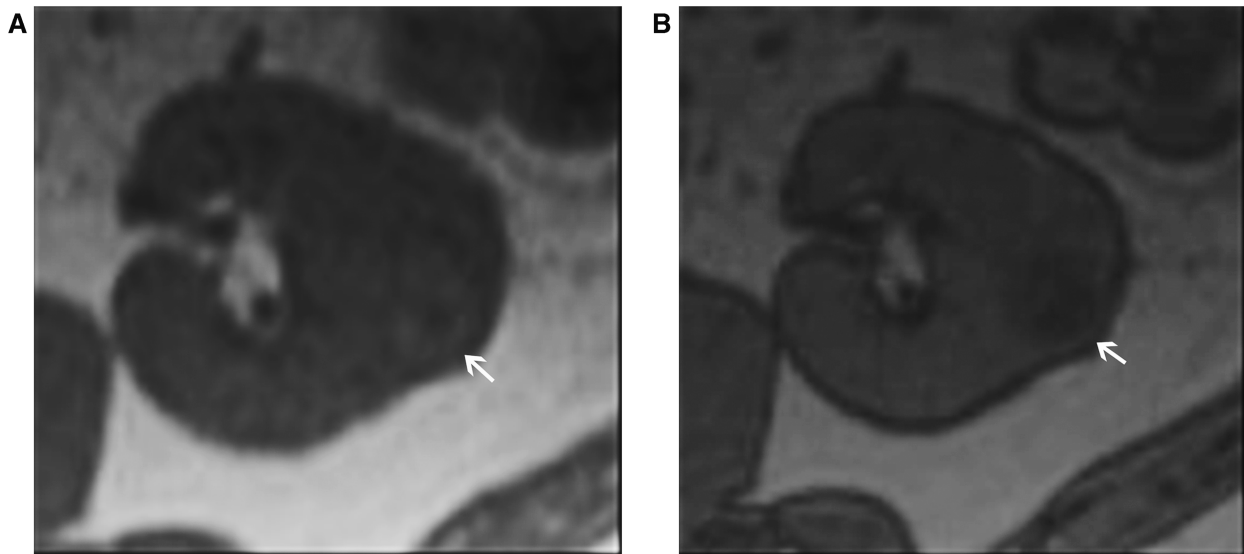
Clear cell renal carcinoma. In-phase (A) and out-of-phase (B) axial MR images show a mass in the left kidney (arrows) with loss of signal intensity on out-of-phase images. There is no India Ink artifact at the interface of the mass and the renal parenchyma.
